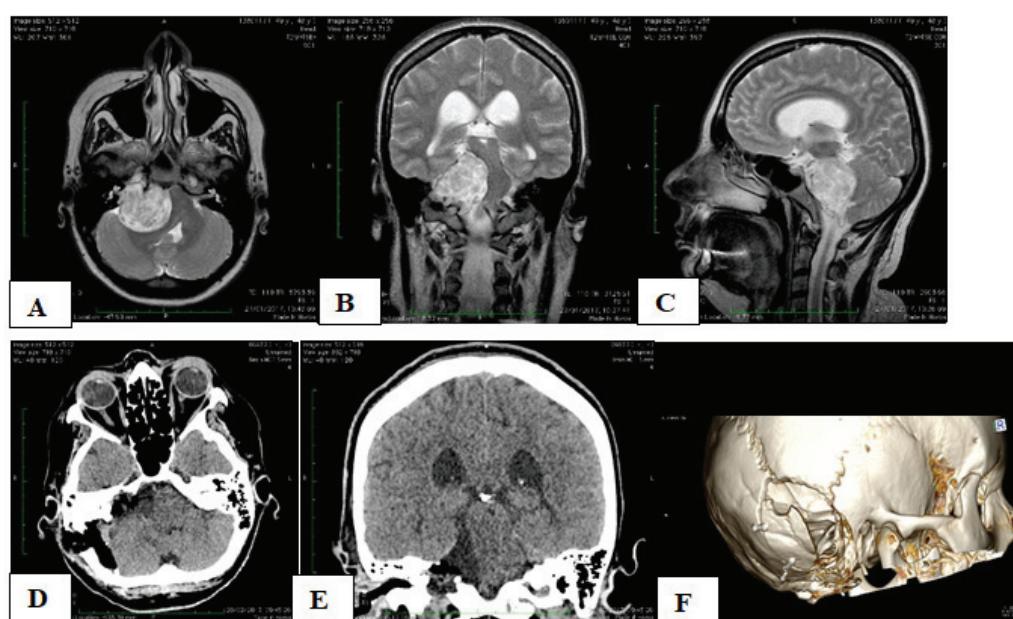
Foramen jugular schwannoma, 50x39x42 mm (MRI preop - Fig. 3A, B, C).
